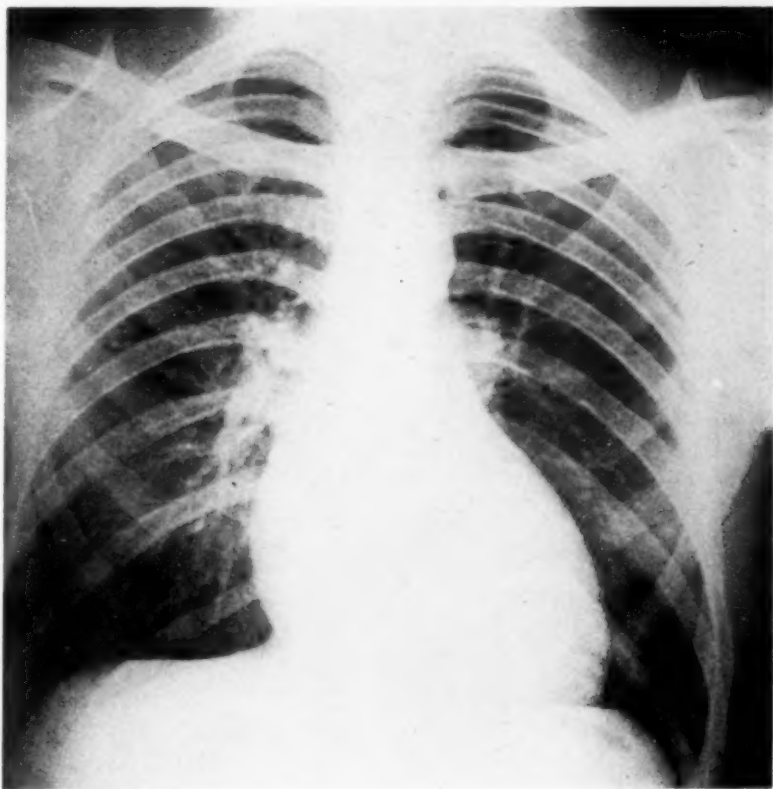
Six foot chest roentgenogram taken October 4, 1943, shows the heart shadow at the upper limits of normal size.
